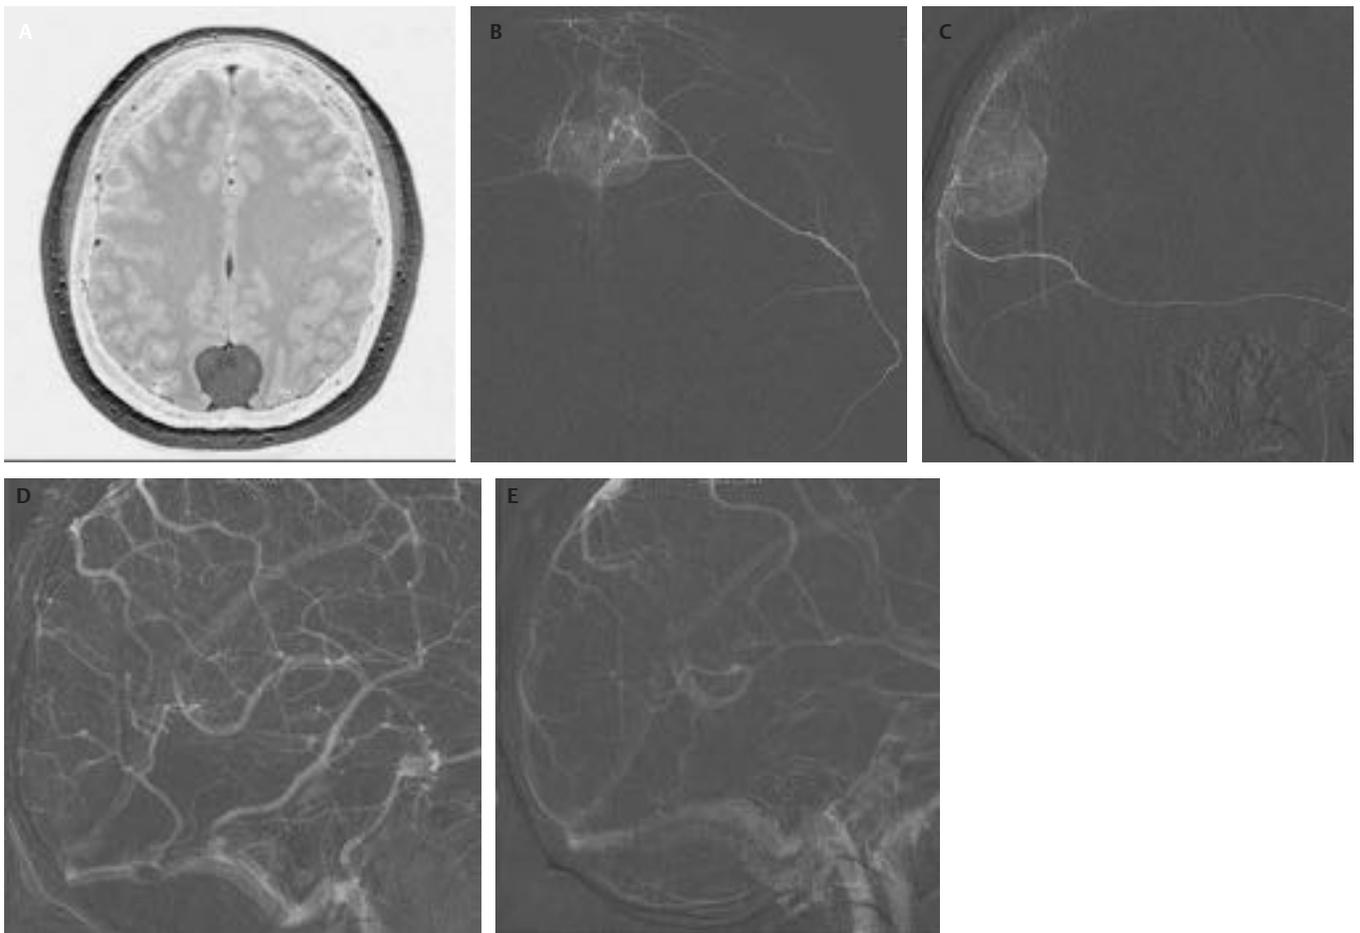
A midline parietal convexity meningioma involving the posterior aspect of the superior sagittal sinus. (A) Axial magnetic resonance imaging (MRI) with contrast demonstrating the typical homogeneous enhancement characteristic of meningiomas. (B) Anteroposterior and (C) lateral superselective angiograms of the left middle meningeal artery. (D) Early and (E) late venous phase internal carotid artery angiograms demonstrating no patency of the posterior aspect of the superior sagittal sinus due to tumor invasion/thrombosis.
